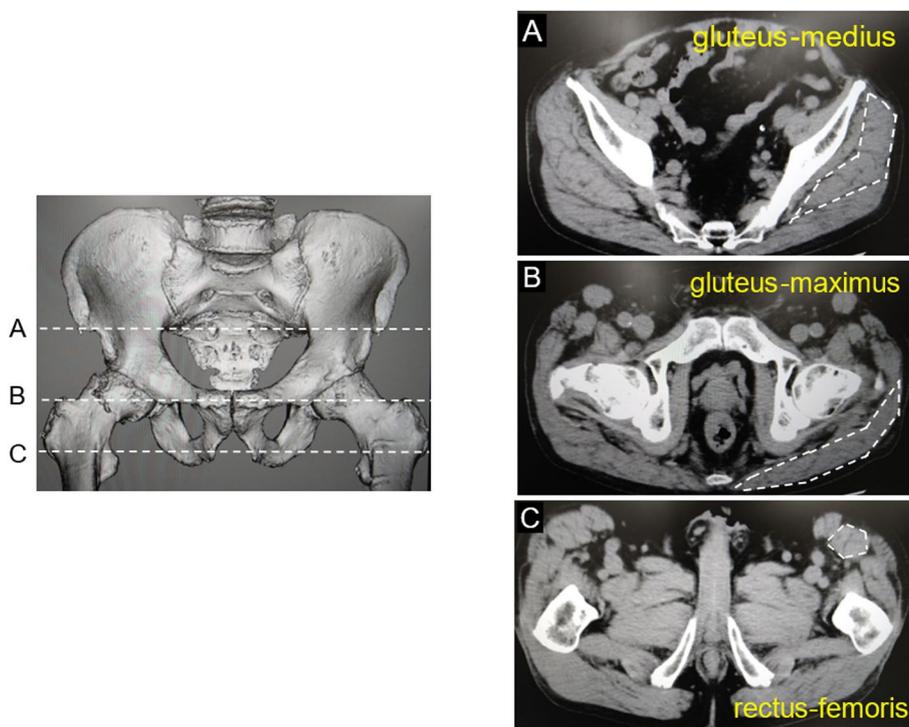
Analysis of muscle cross-sectional area and CT values. A The gluteus medius was measured at the level of the anterior superior iliac spine. B The gluteus maximus was measured at the level of the greater trochanter. C The rectus femoris was measured at the level of the lesser trochanter
